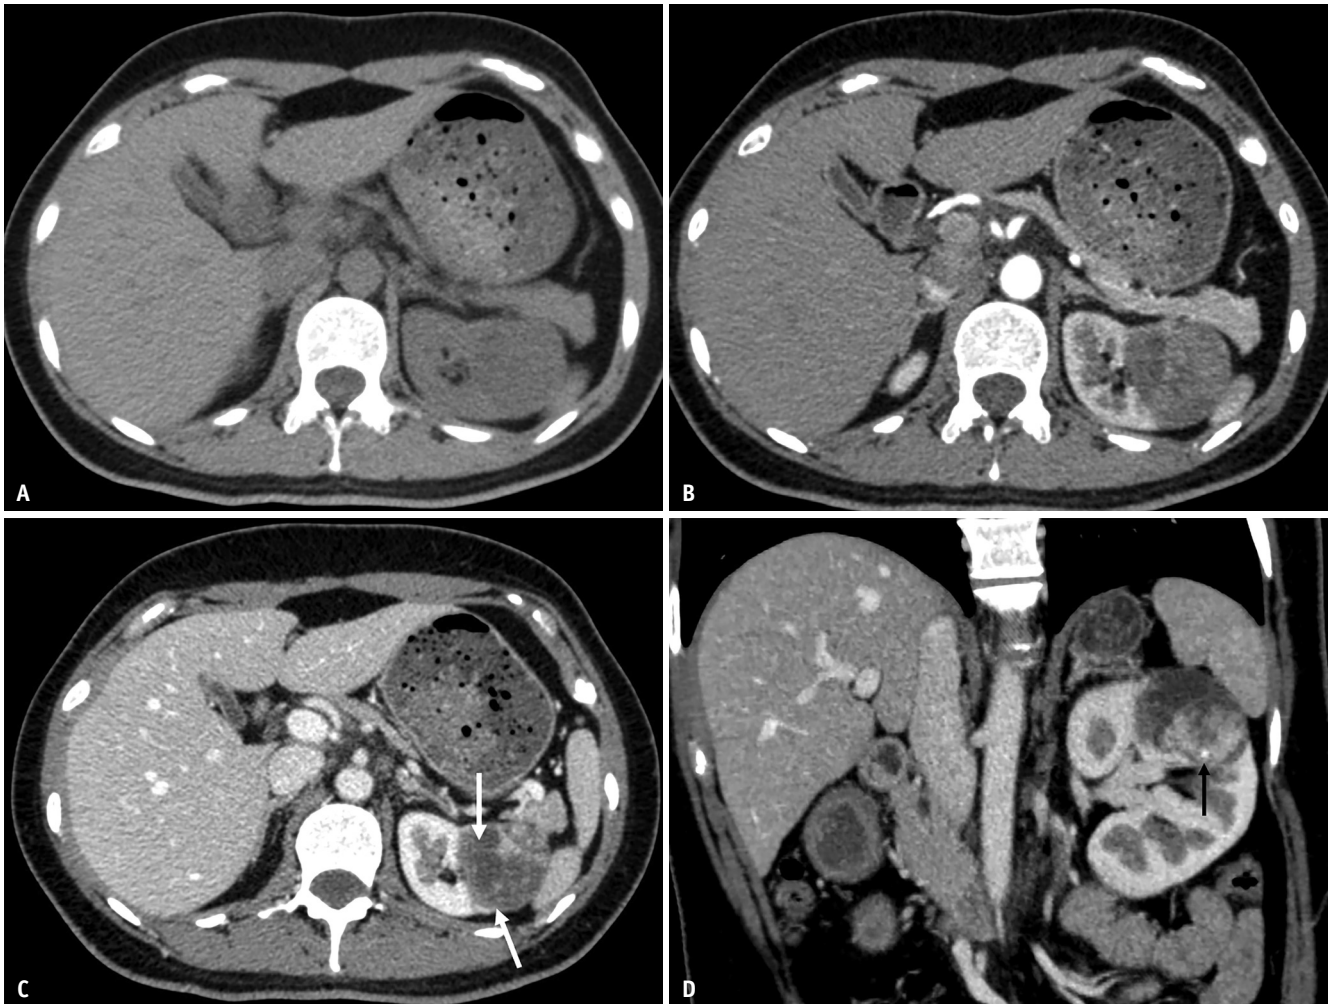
A 37-year-old female with predominantly solid fumarate hydratase-deficient renal cell carcinoma with somatic mutation in the left kidney. A-D. An unenhanced CT image (A) shows a soft tissue mass mixed with a low-density area. Corticomedullary (B) and nephrographic (C, D) phase CT images show the eccentric location of the solid portion with a thin septum (white arrows) and calcification (black arrow).
